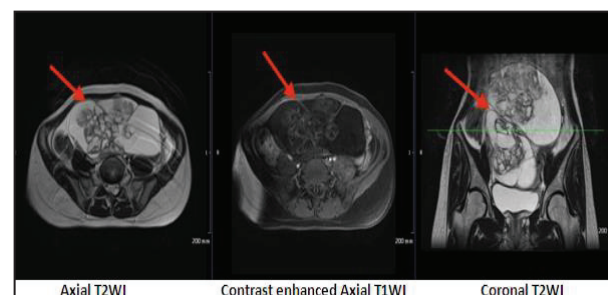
MRI pelvis images showing right adnexal mass (arrow) with malignant features as described
